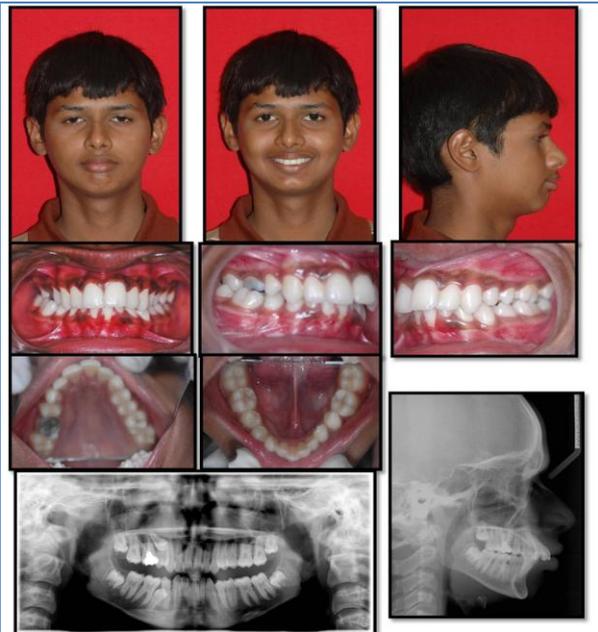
Pre-treatment photos of the patient with lateral Cephalogram and Orthopantomogram.
